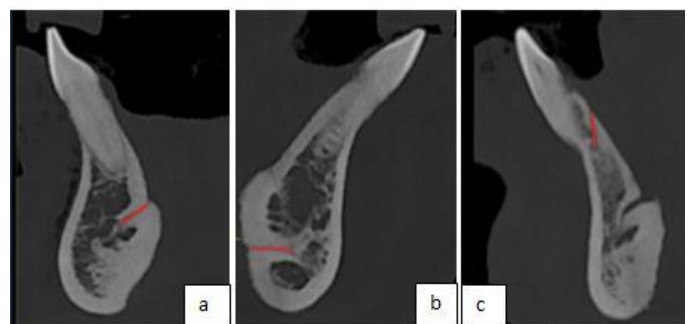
CBCT showing the travel direction of lingual foramina
